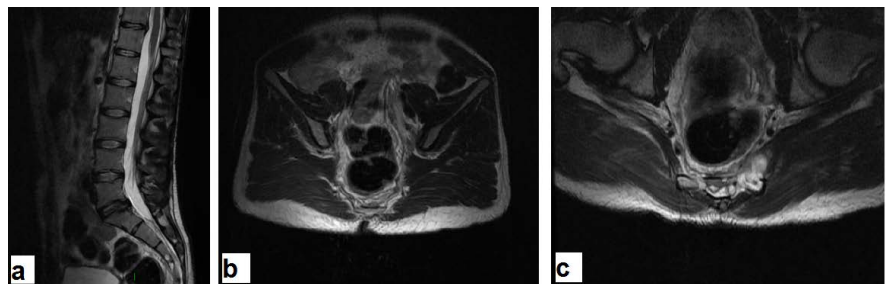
The 1 year postoperative cerebrospinal MRI that show no evidence of residual tumor, no recurrence and no other localization. (a) Axial T2-weighted image. (b) Coronal T2-weighted image. (c) Axial T2-weighted image.
